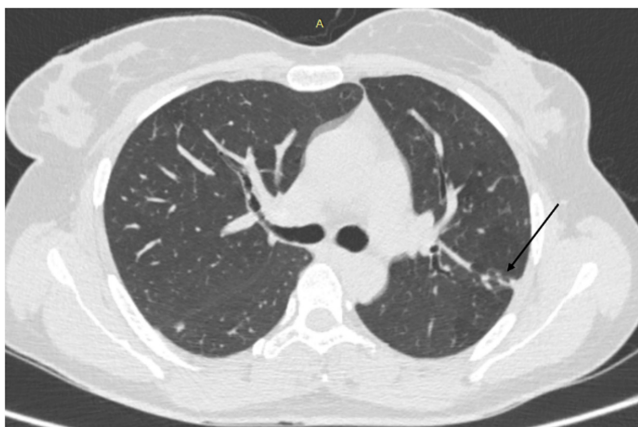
HRCT Chest axial image just distal to the carina shows a focal patchy area of fibrotic change in the apico-posterior segment of the upper lobe of the left lung, as denoted by the black arrow.
